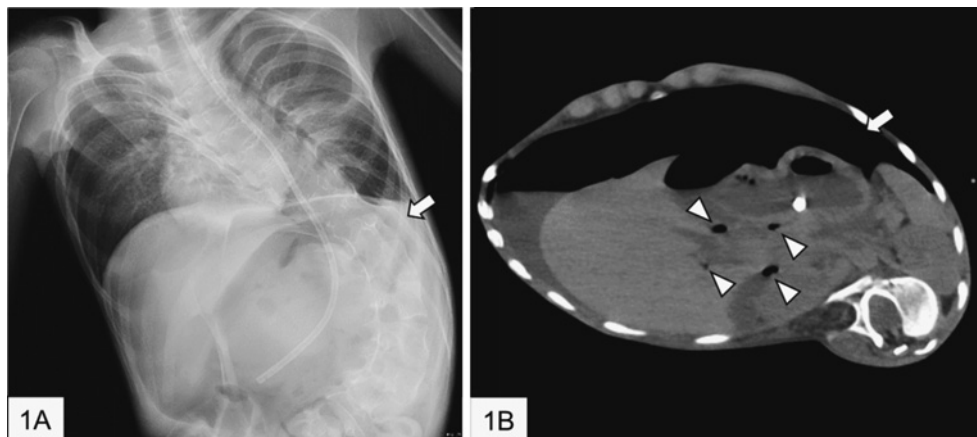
Abdominal radiograph and computed tomography image
